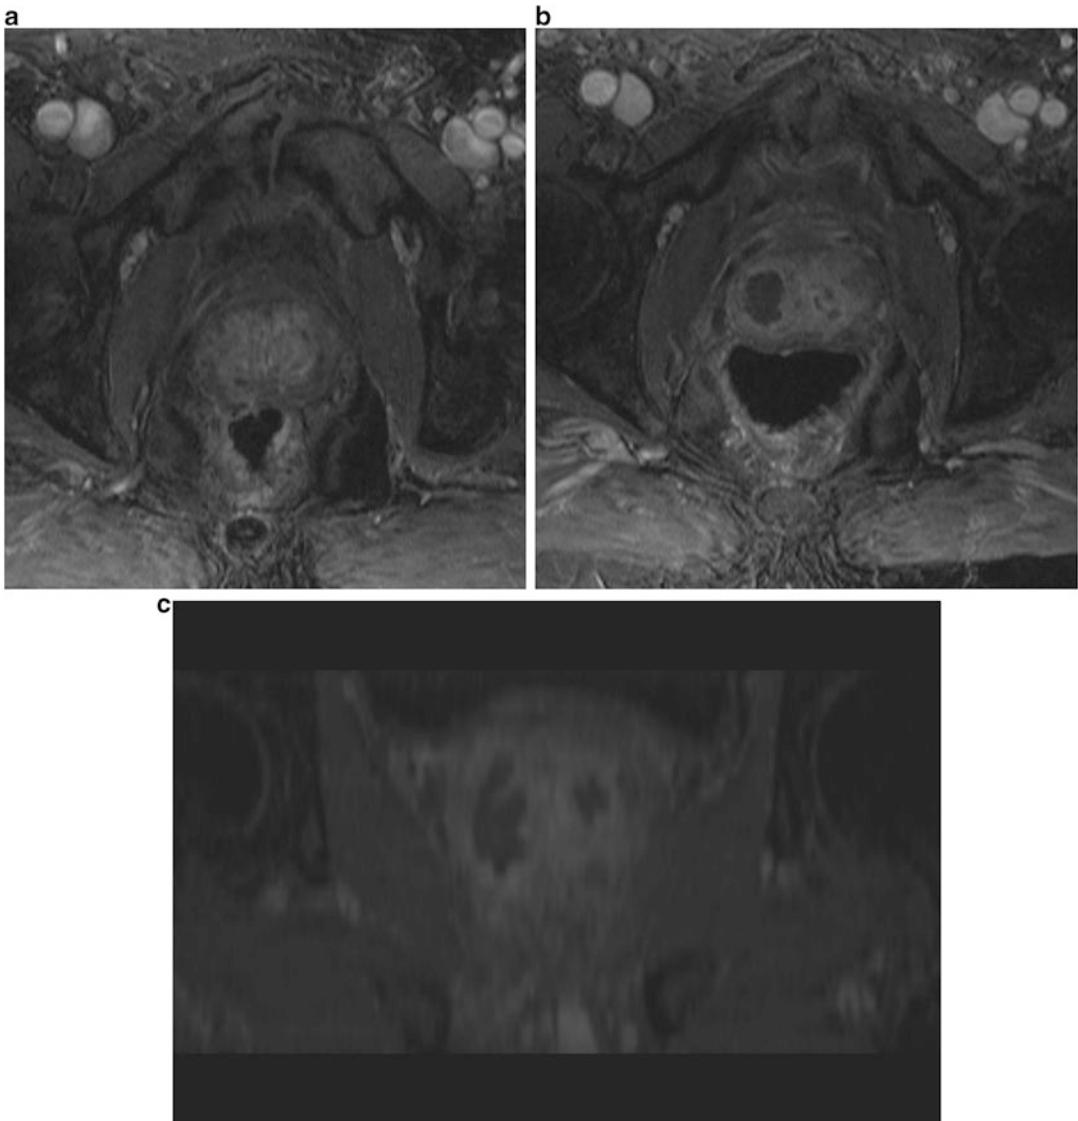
Treatment effect in single fiber phase of WST-09 study. (a) Pretreatment MRI—post-gadolinium image. (b) Posttreatment MRI: 1 week post-gadolinium image
